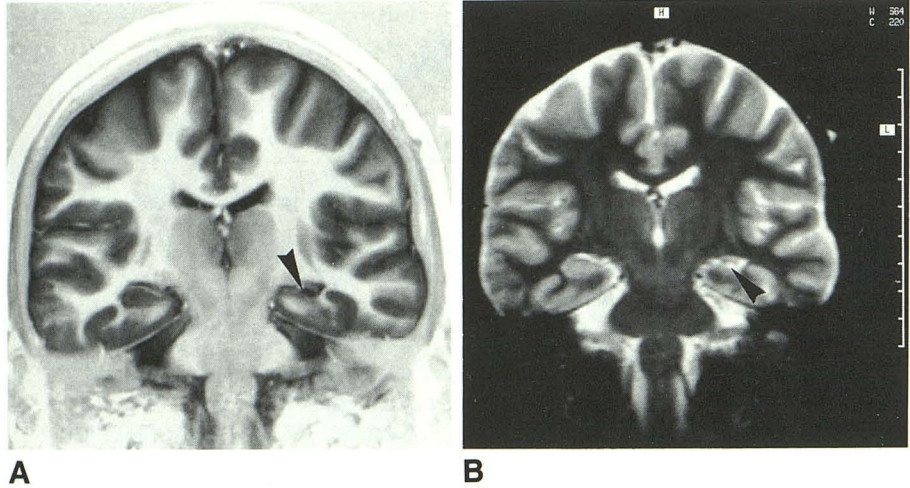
A, Severe atrophy and marked signal hypointensity (arrowhead) is seen on a T1-weighted image (3500/26; inversion time, 300 ms; section thickness, 5 mm) in the right hippocampal body of an 18-year-old man with a history of febrile convulsions complicated by left hemiparesis.
